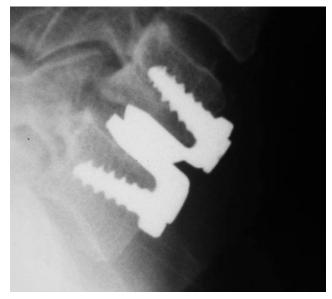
Lateral x-ray of patient who had the motor vehicle accident (MVA) after surgery. Image provided by Medtronic.
